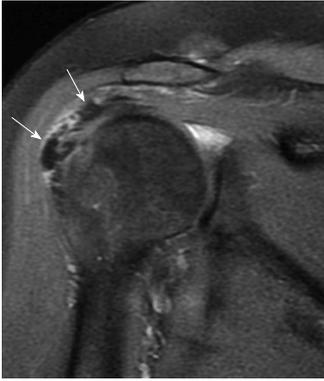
Calcific tendinopathy. Coronal oblique fat-sat proton-density-weighted image showing focal areas of signal void (calcifications) within the distal supraspinatus tendon fibres (arrows). Diagnosis was confirmed by ultrasonography.
